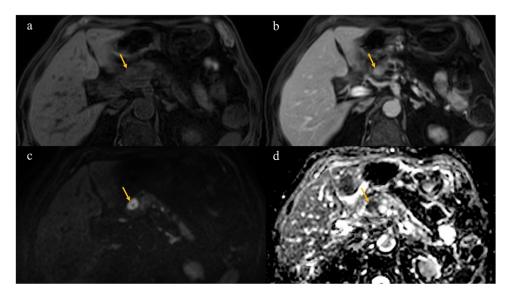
Magnetic resonance T1-weighted images with fat saturation before (A) and after extracellular gadolinium-chelate administration in portal venous phase (B) reveal an enhancing nodule in the neck of the pancreas (arrows). The same nodule shows restriction to diffusion, seen as high signal on high b-value diffusion weighted-image (C) and low signal on the apparent diffusion coefficient (ADC) map (D).
